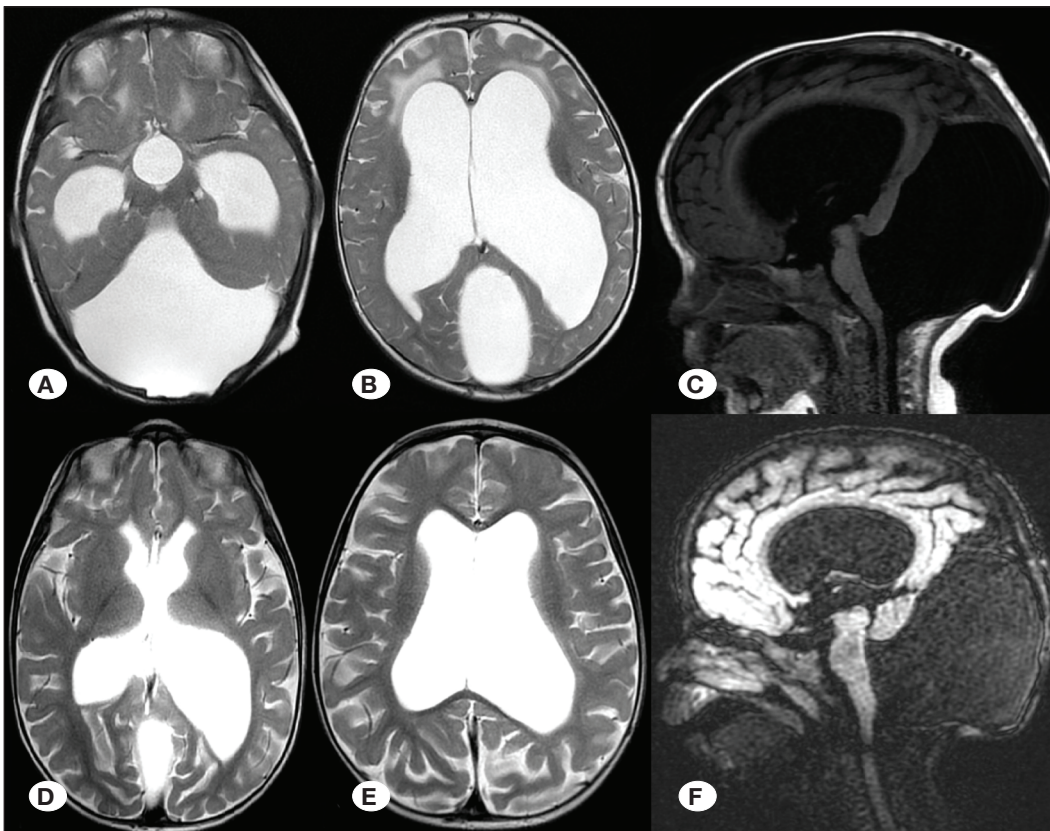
An 11-month-old female child with Dandy-Walker malformation and hydrocephalus. Preoperative axial T2-weighted (A, B) and sagittal T1-weighted (C) images show communicating hydrocephalus and cerebellar hypoplasia. The patient underwent endoscopic third ventriculostomy plus aqueductoplasty, and postoperative axial T2-weighted (D, E) and sagittal T1-weighted (F) magnetic resonance imaging scans confirm the decrease in ventricle size.
